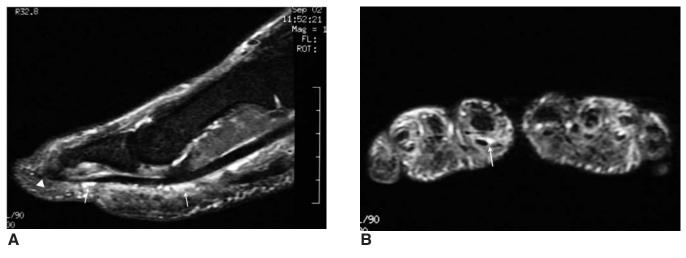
Toe dactylitis. Sagittal (A) and axial (B) FSPGR (fast spoiled gradient-echo) T1-weighted image with fat saturation obtained after contrast administration showing fluid/synovitis together with vascularization in the flexor synovial sheaths (arrows) and normal flexor entheses and adjacent bones (arrowhead).
